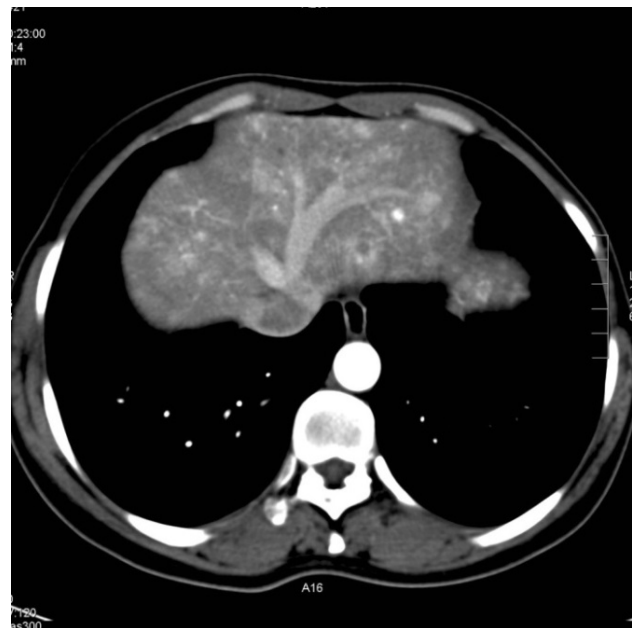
Axial CT in the arterial phase earlier shadow of hepatic veins suggesting of arterioportal shunt.
